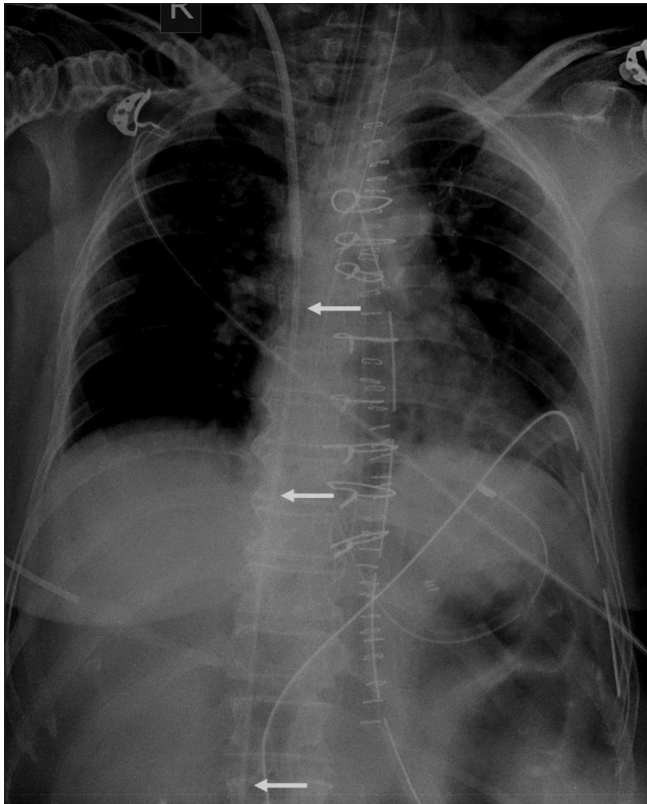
Frontal chest radiograph shows malposition of a Swan-Ganz catheter (arrows) in the inferior vena cava
